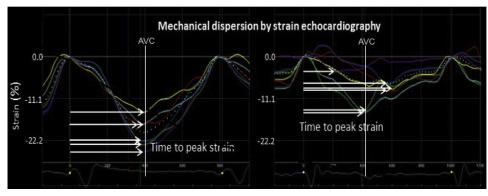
Mechanical dispersion by myocardial strain imaging. Longitudinal strain curves from apical four-chamber view displaying six of the 18 LV segments used to calculate mechanical dispersion. *(Left)* Mechanical dispersion in a patient with ChHD without ventricular arrhythmias. *(Right)* A patient with ChHD who presented with LV dysfunction and a previous episode of sustained ventricular tachycardia. The time to maximal myocardial shortening of longitudinal strain was markedly dispersed compared to the patient without arrhythmias. *AVC*, Aortic valve closure.
